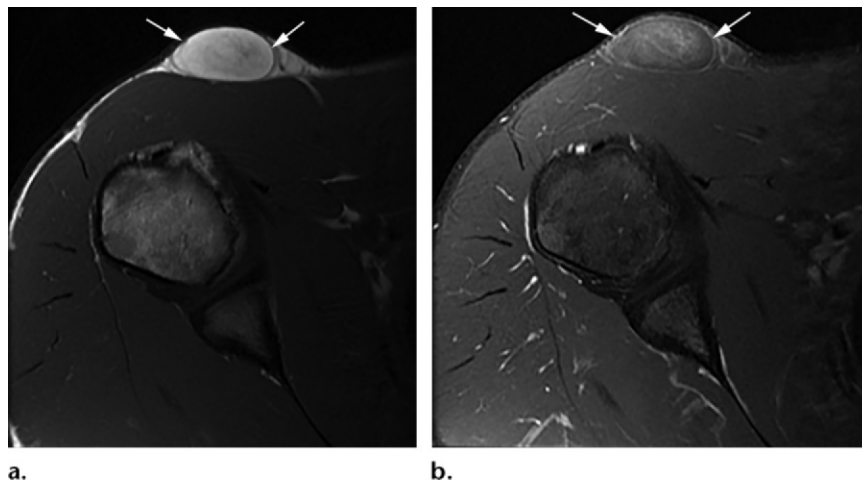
Spindle cell (pleomorphic) lipoma in an 18-year-old woman with a painless right shoulder mass. (a) Axial T1-weighted MR image shows a superficial, encapsulated fat-containing mass (arrows) in the anterior shoulder. There is indistinct, wispy hypointense signal within the mass. (b) Axial postcontrast fat-saturated T1-weighted MR image shows suppression of the fat signal intensity and mild enhancement of the indistinct hypointense areas. Surgical excision and pathologic evaluation confirmed spindle cell lipoma.
